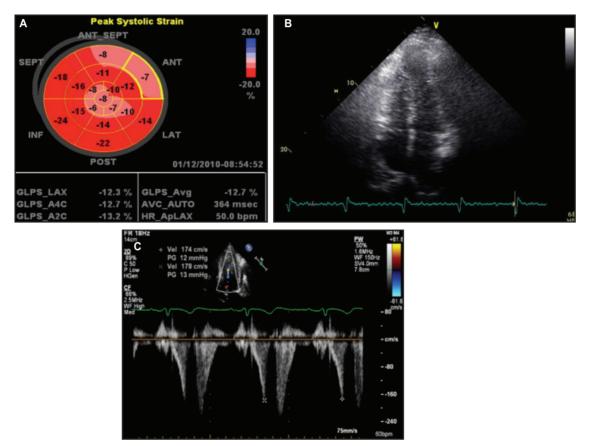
A). Myocardial strain measured by speckle tracking echocardiography showing typical reduced apical strain in apical variant hypertrophic cardiomyopathy. (N.B. ANT: Anterior, LAT: Lateral, Post: Posterior, Inf: Inferior, Sept: Septal, GLPS: Global Longitudinal Pattern Strain, LAX: Long axis, A4C: Apical 4 Chamber view, A2C: Apical 2 Chamber view, HR: Heart Rate). B). Apical HCM with apical pouch. C). Typical Doppler of apical HCM with apical pouch showing systolic and diastolic flow (N.B. Vel: Velocity, PG: Pressure Gradient)
